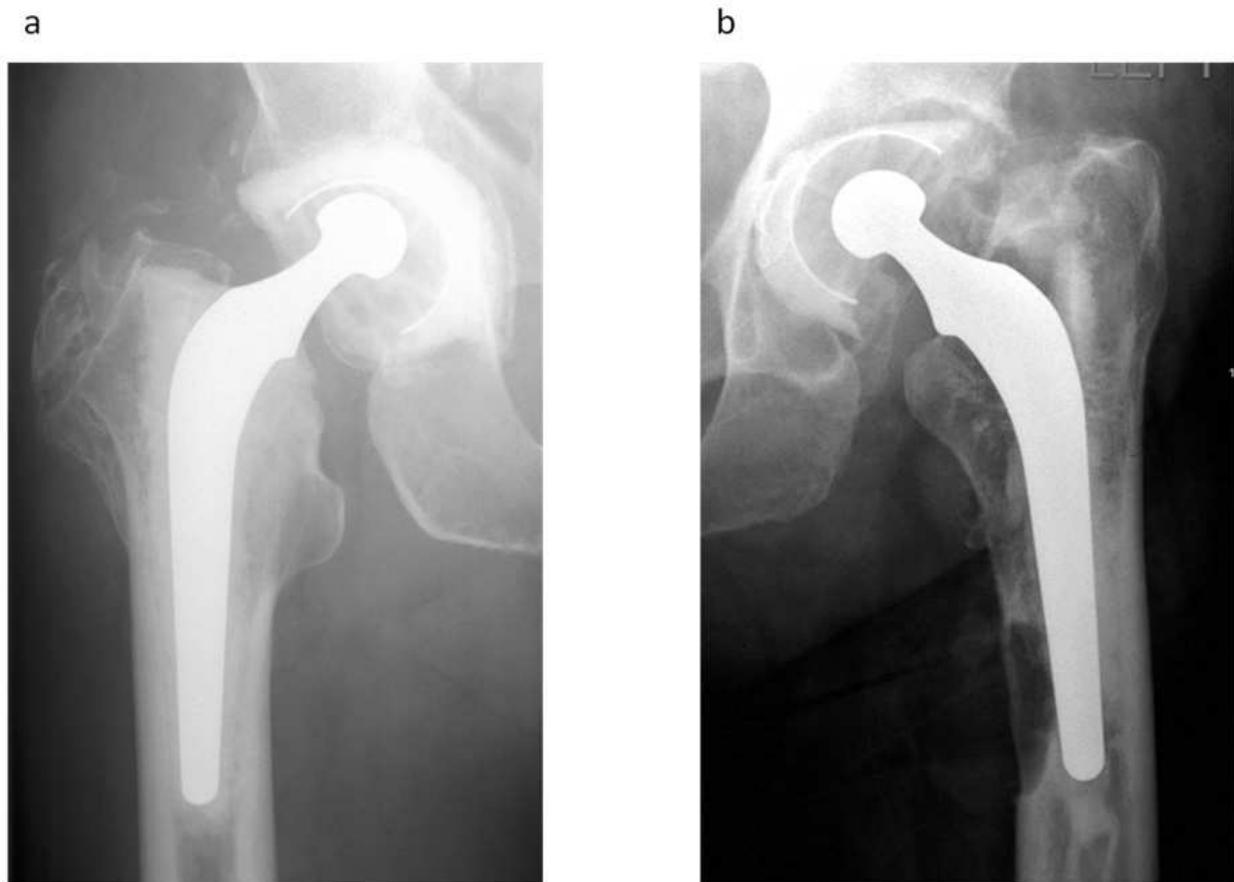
Patients exhibit variable osteolytic responses to wear debris. a) radiograph showing marked polyethylene wear, but no osteolytic response, b) radiograph showing mild wear but pronounced femoral and acetabular osteolysis with prosthesis loosening.
